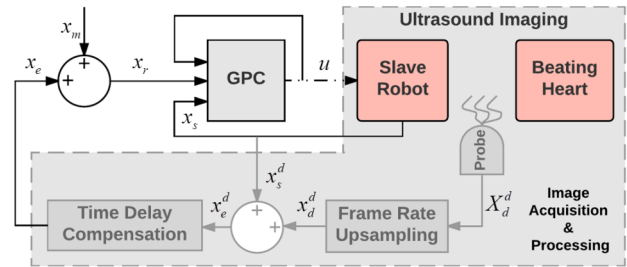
Motion compensation control system. Here,  $X_d^d$  indicates the measured robot-heart distance by ultrasound machine, which is slowly sampled and delayed. Also,  $x_s^d$ ,  $x_s^d$ , and  $x_e^d$  are the robot-heart distance, slave robot position, and beating heart position with a fast sampling rate, respectively. The superscript  $d$  indicates the data is delayed. The predicted beating heart position is indicated by  $x_e$ , which has both high sampling rate and no delay.
